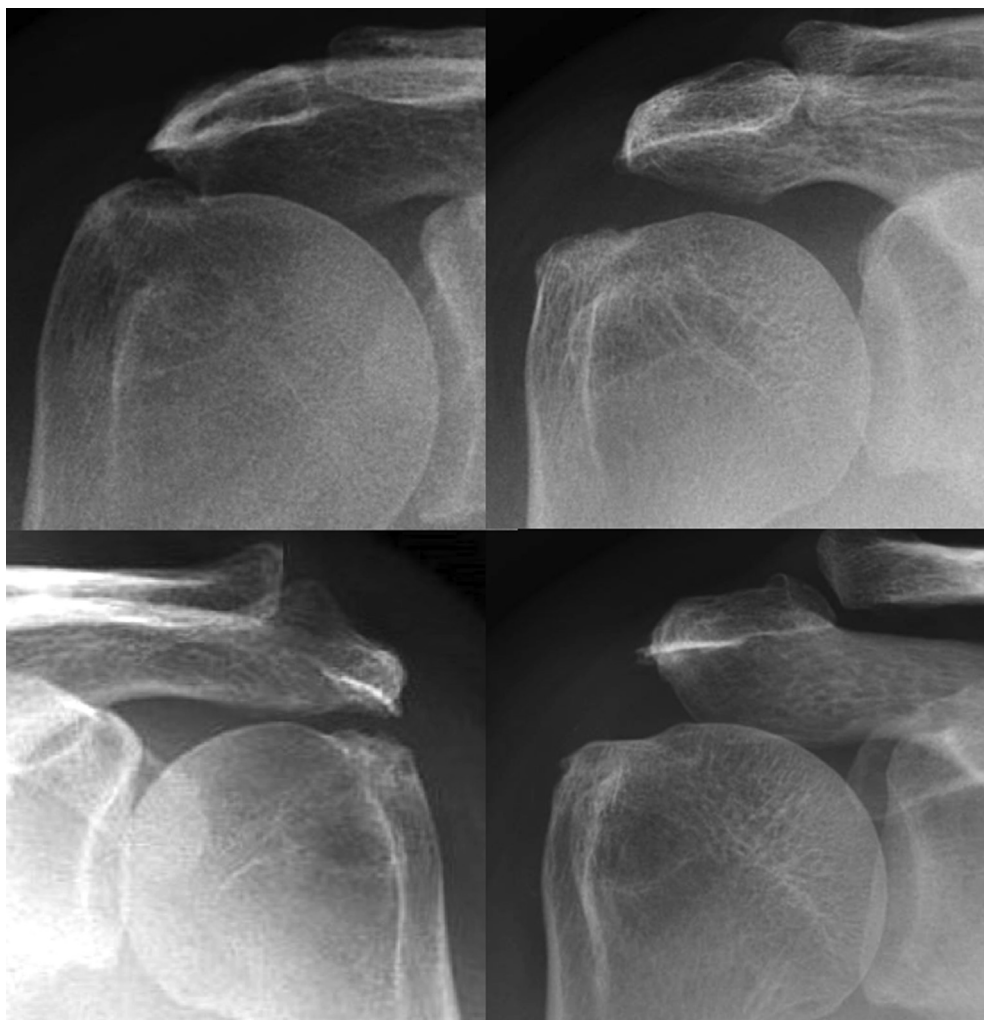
Radiographs showing various presentation of SLAM signs all associated with a rotator cuff tear. SLAM, sharpened lateral acromial morphology.
